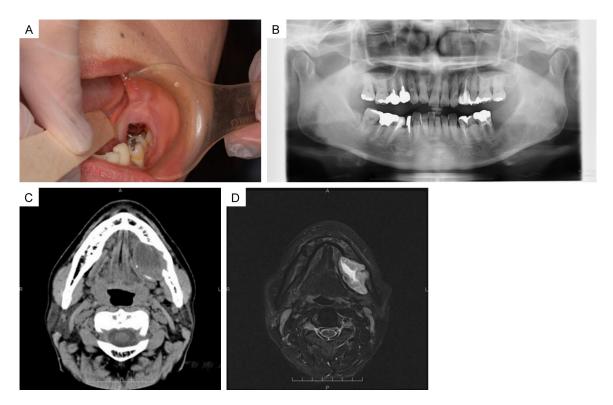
Intraoral findings and panoramic radiograph, computed tomography (CT), and magnetic resonance imaging (MRI) findings at initial visit. A: Bone expansion was found in the lingual alveolar area of the left mandibular first molar to left mandibular second molar. B: Panoramic radiograph finding. A unilocular X-ray image was observed in the mandible from the left mandibular first molar to the left mandibular ramus. C: CT findings. The CT number inside the lesion ranged from 15-40 Hounsfield units, which was thought to be a fluid collection. The lingual cortical bone of the left mandibular molar was expanding and partially disappeared. D: MRI finding. A mass lesion of $45 \times 25 \times 37$ mm in size with a heterogeneous internal fluid collection in the mandible corresponding to a left mandibular molar was observed.
